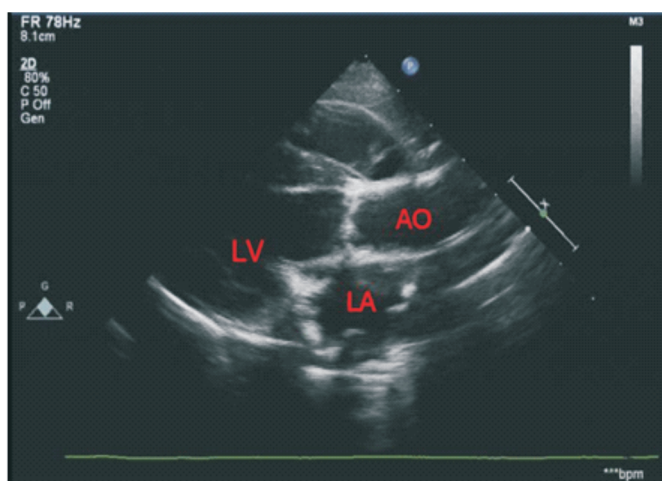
Trans-thoracic left parasternal long axis B-mode echocardiogram.
